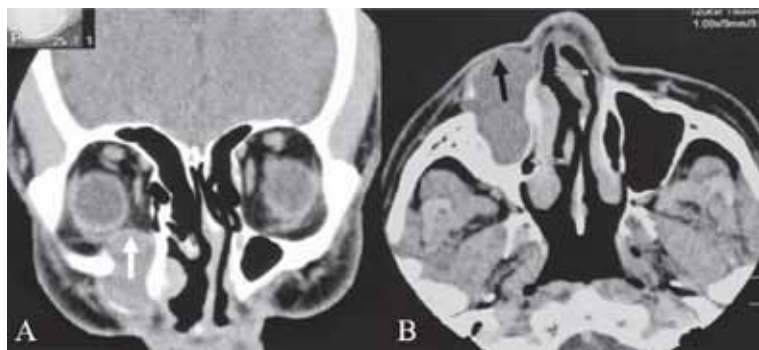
Coronal (A) and Axial (B) post-contrast CT scan showing complete opacification of right maxillary sinus with an expanding mass invading the orbital floor and compressing the globe (white arrow). The mass also breaches the anterior wall of the sinus causing cheek swelling (black arrow).
